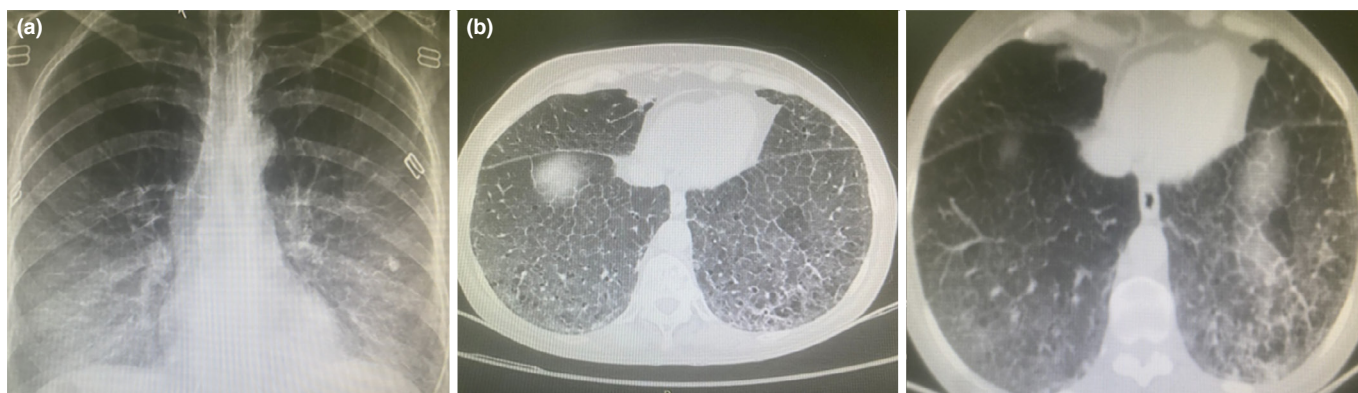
(a) Chest X-ray of patient. (b) Thorax computed tomography of patient
